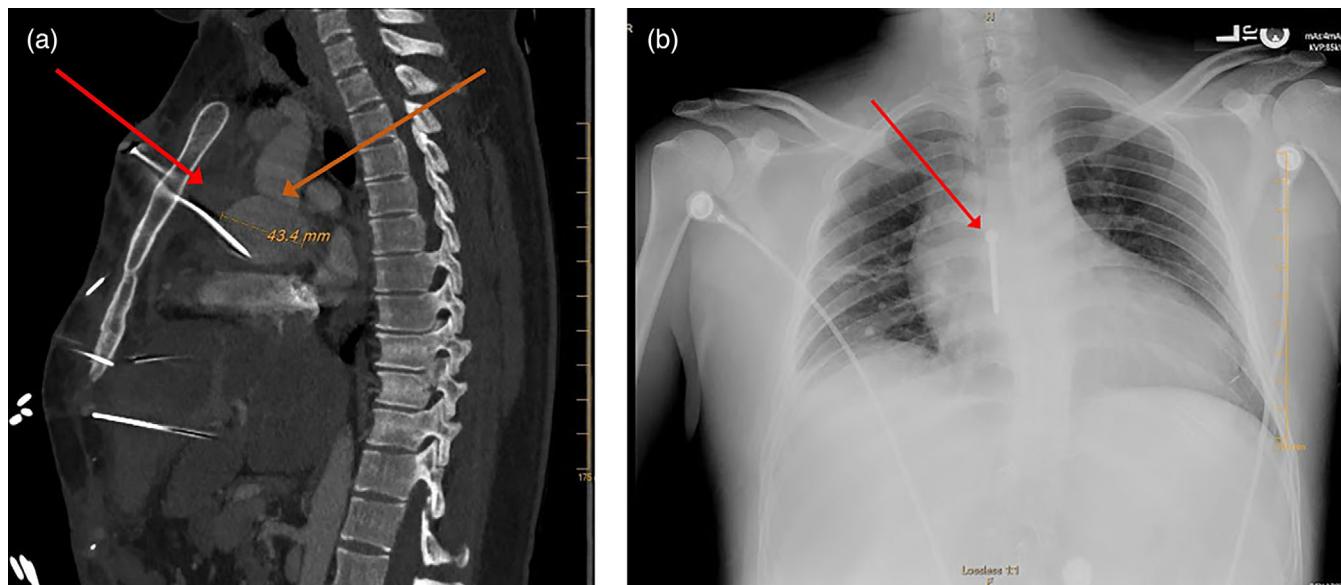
Lateral radiograph identifies metallic foreign body that has penetrated through the sternum and mediastinum
